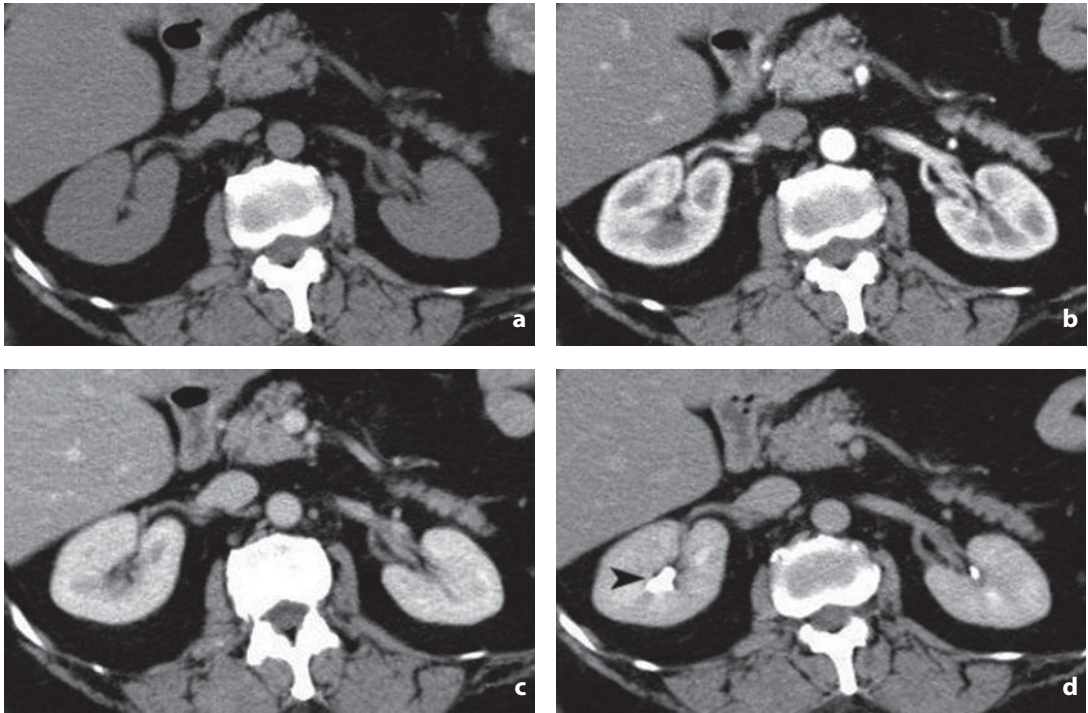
Computed tomography. Multiphase dynamic study. Kidney. a Baseline image. The cortex and medulla cannot be differentiated. b Arterial or corticomedullary phase. Greater enhancement of the cortex than the medulla. c Venous or nephrographic phase. Uniform hyperattenuation of the renal parenchyma. d Excretory phase. Enhancement of the pyelocaliceal cavity (*arrowhead*)
